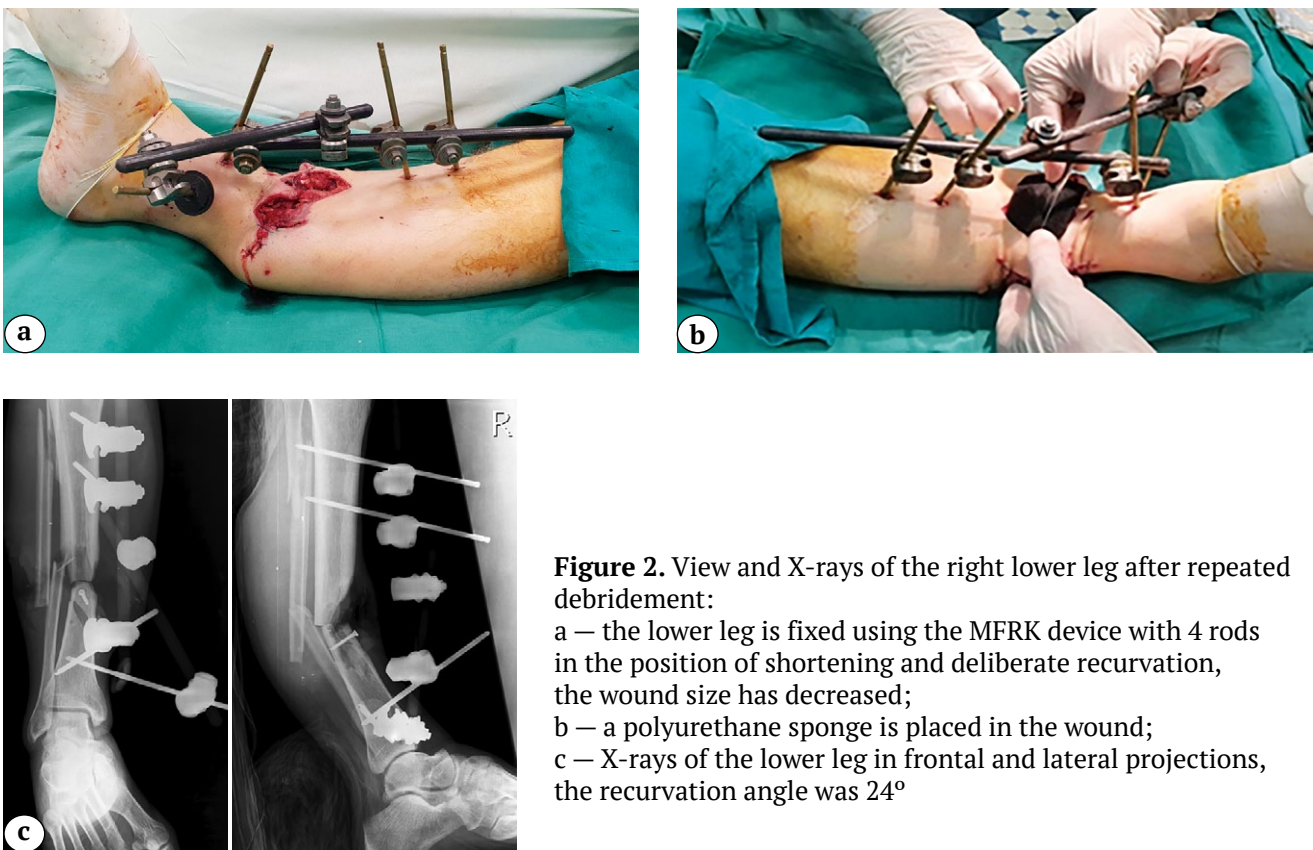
View and X-rays of the right lower leg after repeated debridement:
